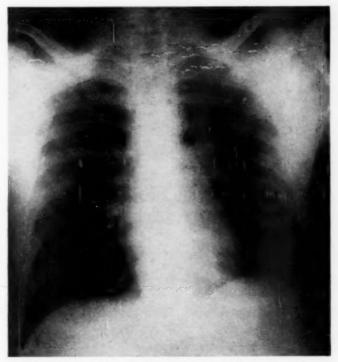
Case 7. Fatal case of meningitis with right paratracheal lymphadenopathy. On autopsy, lesion was found in right lower lobe. Not detected by roentgenogram.
